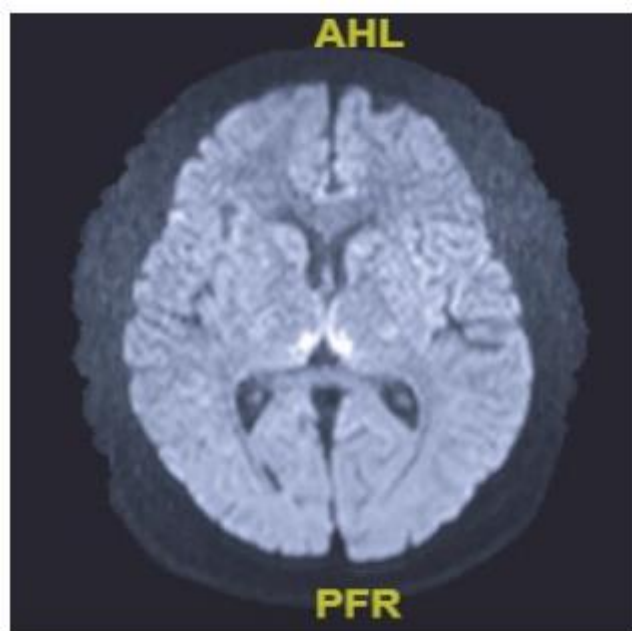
Brain MRI on the eighth day of hospitalization. Wernicke encephalopathy is indicated by an aberrant increase in T2 signal in periaqueductal gray matter and medial thalami.
